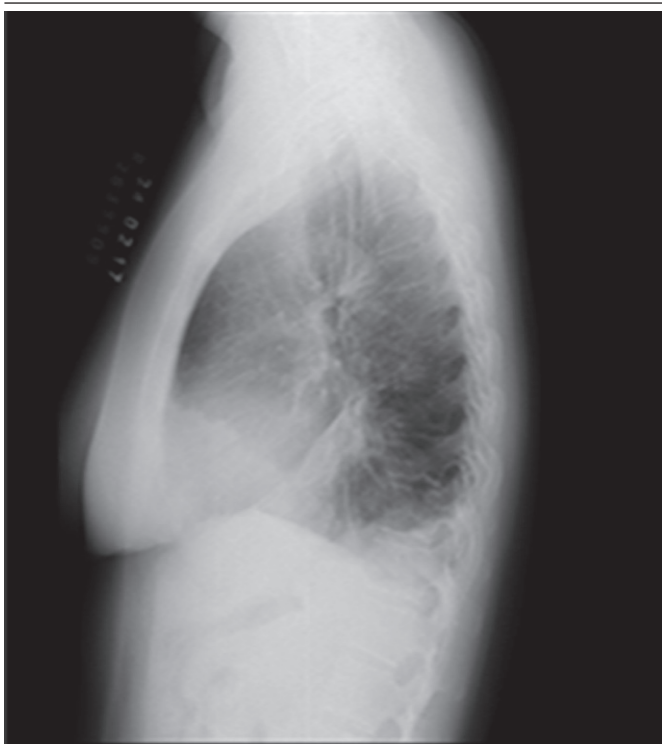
Lateral chest X-ray. Opacity in right lung base and in midfields and left lung base, due to air space filling lesions
